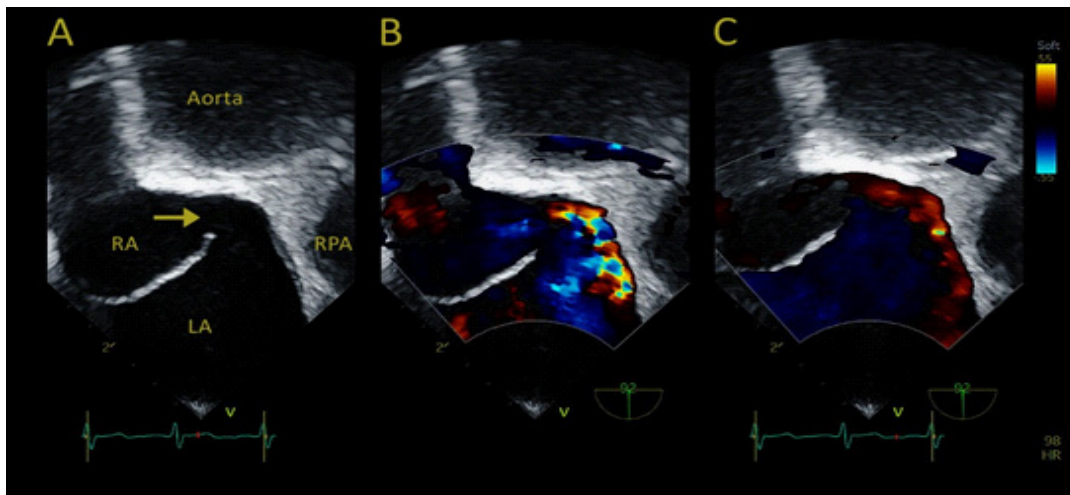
Trans-esophageal-echocardiography. Bicaval view (A) showing a PFO (arrow). RA right atrium, LA left atrium, RPA right pulmonary artery. Colordoppler showing a continuous right-to-left flowthrough the PFO both on (B) systole and (C) diastole.
